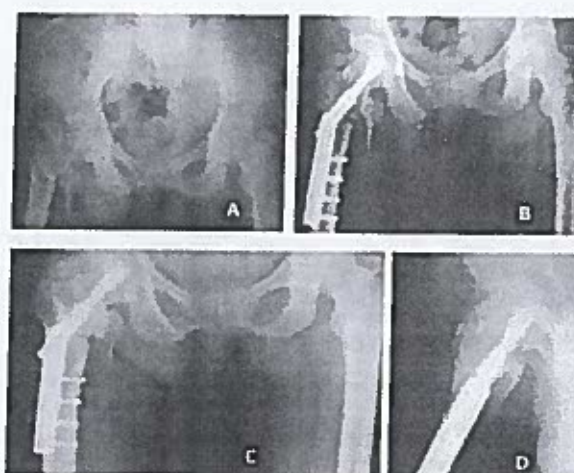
Patient treated by DHS. A) preoperative; B) postoperative; C) X-ray; D) follow up X-ray at 6 months.
